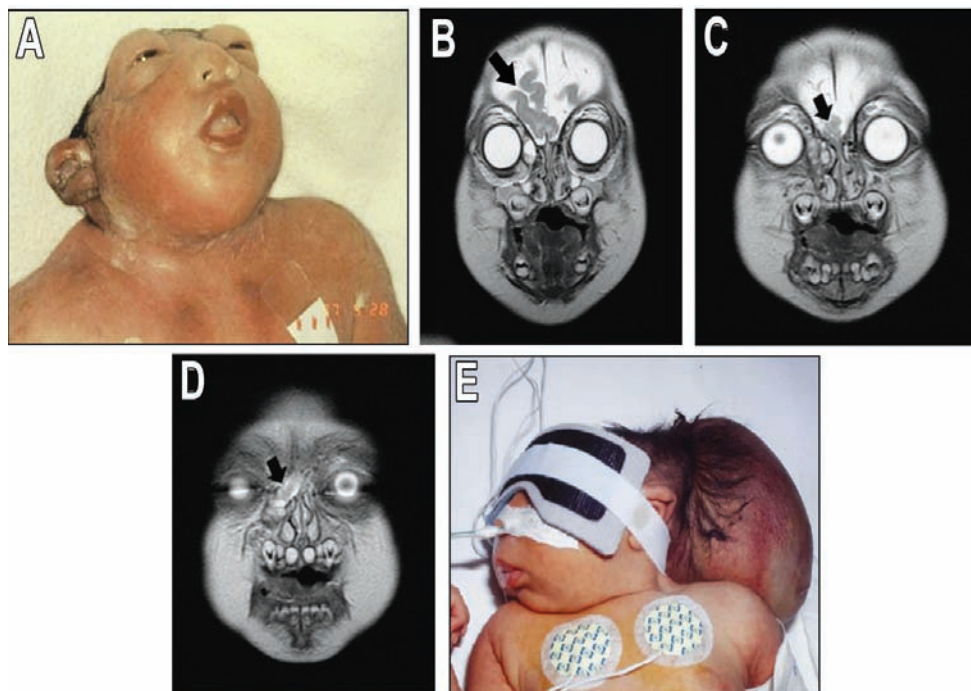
Images showing cranial neural tube defects: A) a newborn with anencephaly. B, C & D) Anterior encephalocele. Sequential coronal MRI scan showing brain herniation through the right nasal bone (arrows in C & D); and E) large posterior encephalocele.
